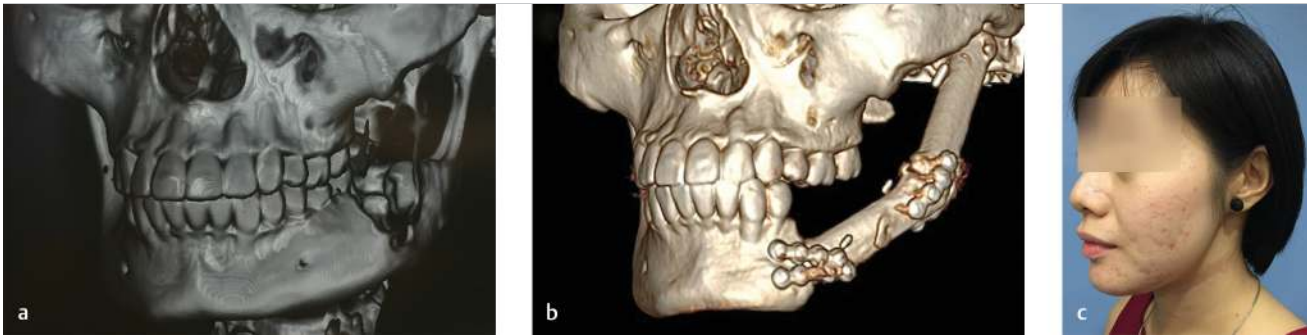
Reconstruction of a segmental mandibular defect with a free fibula osteoseptocutaneous flap. (a) Preoperative computed tomography (CT) three-dimensional reconstructed image of a mandibular ameloblastoma in a 33-year-old woman. (b) Postoperative CT three-dimensional reconstructed image showing reconstruction of the mandibular body and angle defect with a vascularized fibula flap. (c) Postoperative appearance 6 months later showing good jaw contour and a well-healed scar in the neck.
